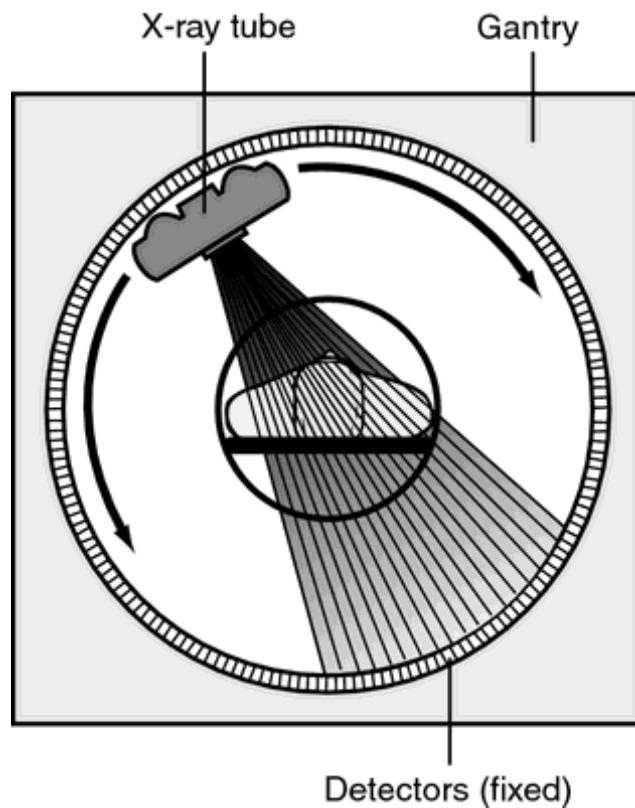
(thefreedictionary.com) & 3B (rgpvexams.com): How modern CT, or Multi-slice Spiral CT (MSCT) is obtained using multiple detectors, a fan-beam and helical acquisition.
